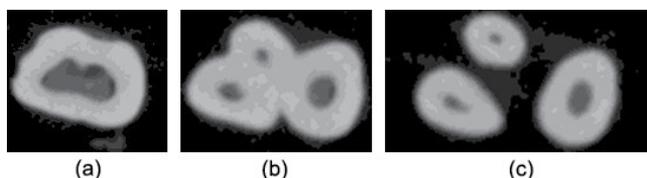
Slices of CBCT images with cross section of different sections (a, b, and c) of the root canal.
